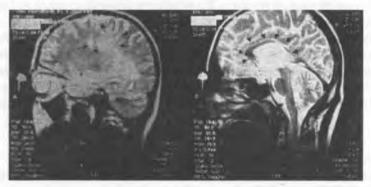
T2-weighted MR images in saggital planes, showing lesion in periventricular area of right parietal lobe and atrophy of corpus callosum
